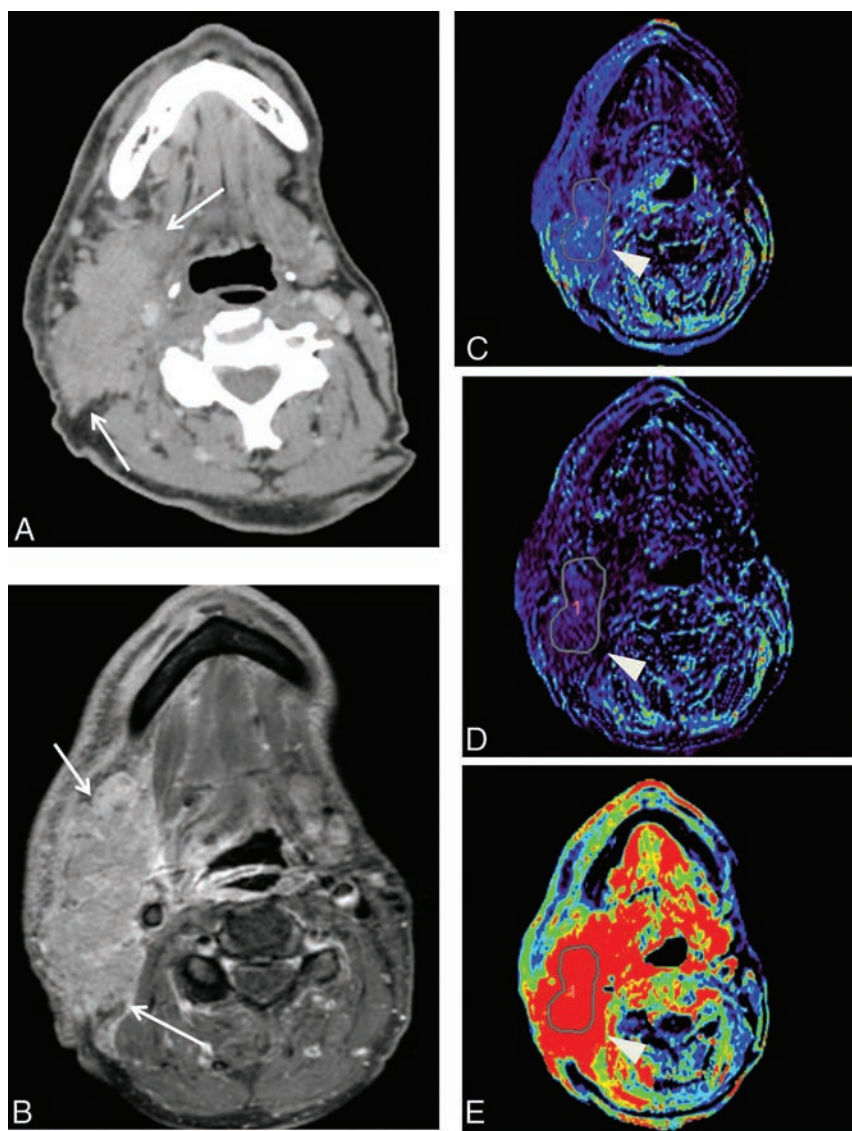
A 52-year-old male patient with squamous cell carcinoma of the right palatine tonsil. Pretreatment axial contrast-enhanced neck CT demonstrates metastatic right level II lymph nodes (A). Parametric maps (C, D, and E) show a lower volume transfer constant ($K^{\text{trans}} = 0.06/\text{min}$), K_{ep} , and area under curve, respectively. Gadolinium-enhanced axial T1-weighted MR imaging of the neck at 12 months post-chemoradiation treatment demonstrates an unfavorable response to treatment (B).
